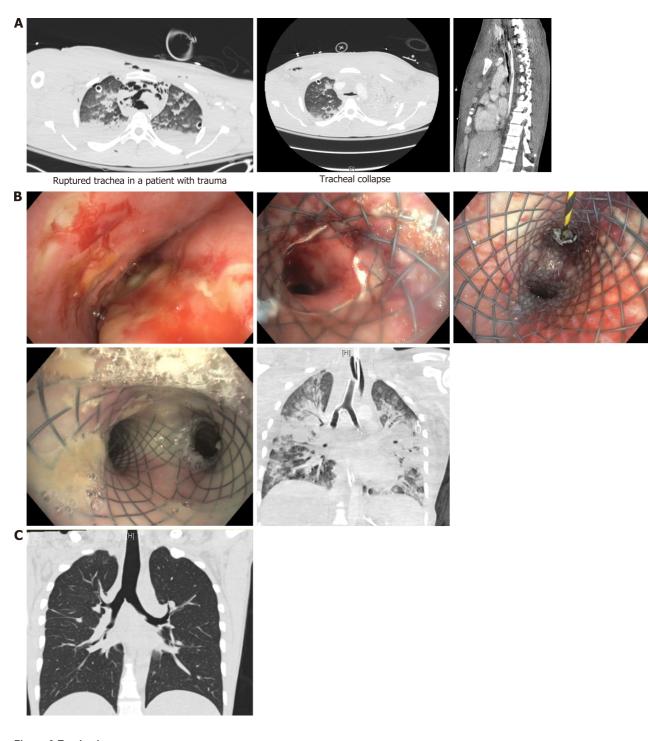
Tracheal surgery. A: Computed tomography scans in an 18-year-old patient showing tracheal rupture following motor vehicle accident; B: With extracorporeal membrane oxygenation support, rigid bronchoscopy was performed followed by placement of Y stent; C: Tracheal tear healed following which Y stent was removed.
